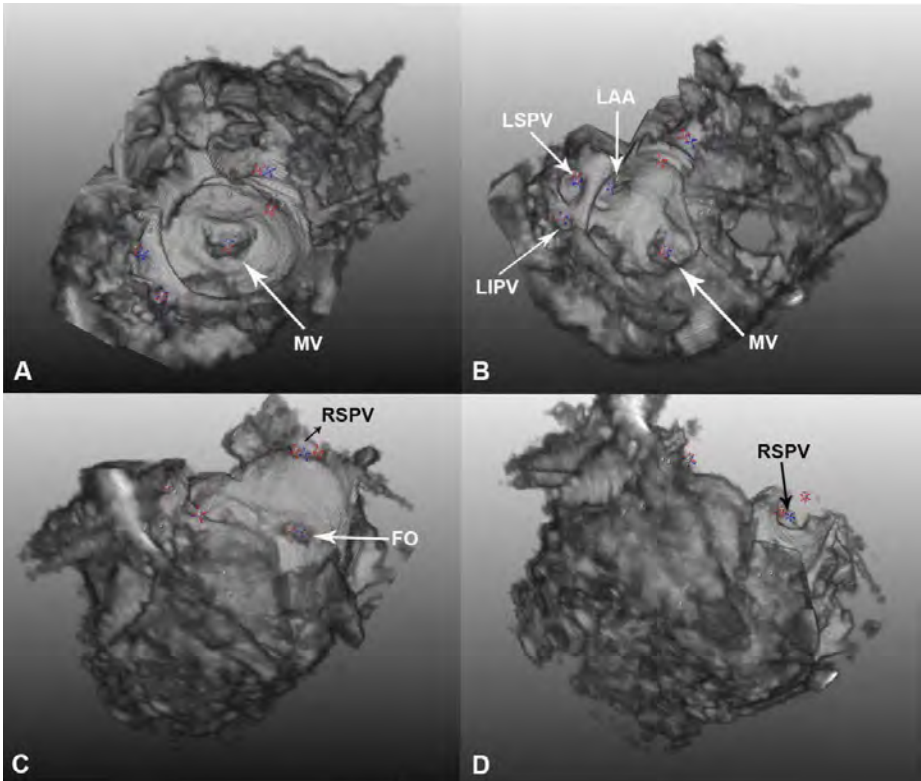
An example of a fused 3D transesophageal echocardiographic dataset with landmarks on the important cardiac structures. Red crosses are the landmarks marked in the CT dataset and blue crosses are the landmarks marked in the fused 3D TEE datasets. The right superior pulmonary vein ostium was not visible in the 3D TEE dataset. FO, fossa ovalis; other abbreviations as in Figure 1 and 2.
